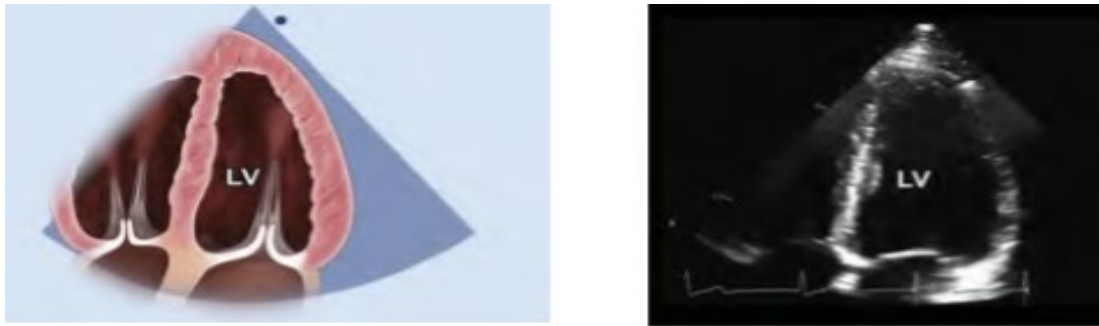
Apical four chamber view focused on the left ventricle and mitral valve. Reproduced with permission from the American Society of Echocardiography. (135)
